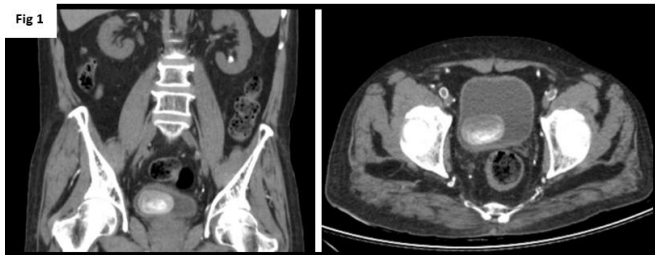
Non-contrast CT of abdomen showing a calculus of heterogeneous density measuring 4.5cm with a Hounsfield unit of 300.
